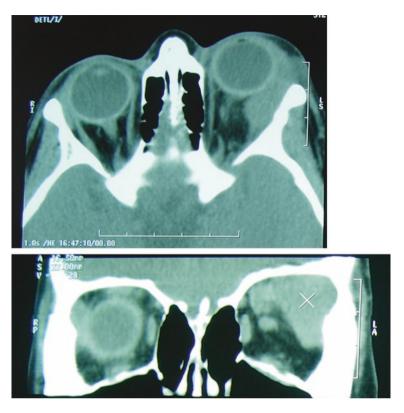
a Demonstrates axial view CT-scan of a patient with tissue infiltration and mass lesion in the lateral of orbital cavity. b Coronal view reveals excavation of the lateral orbital wall due to the tumor
